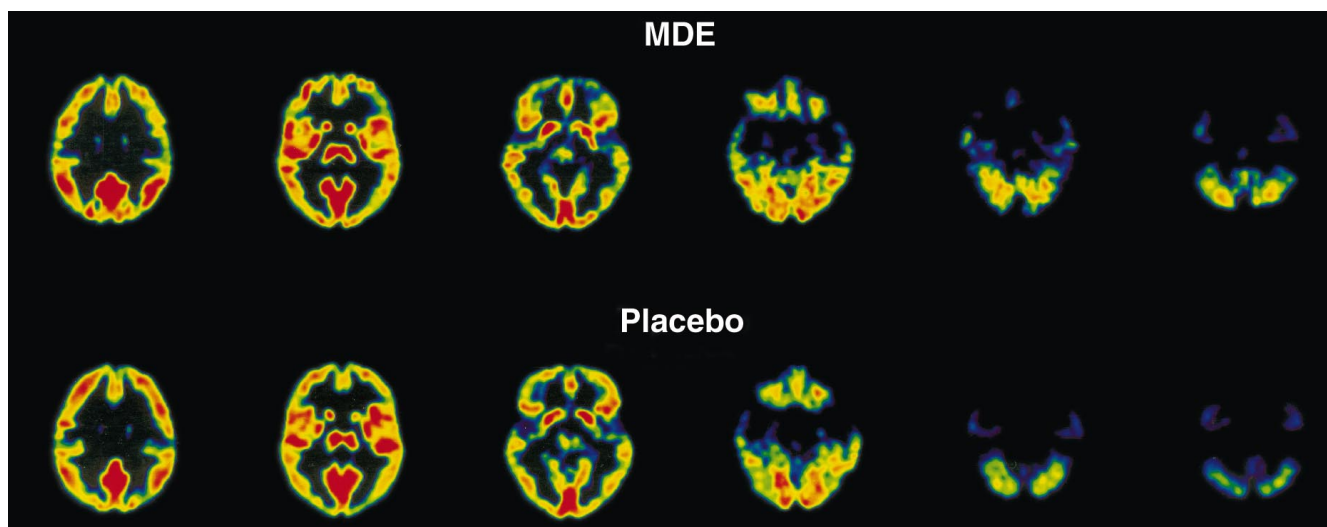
Top row Transaxial ^{18}F FDG PET slices (normalized to global glucose metabolism) under MDE; bottom row corresponding slices under placebo. There is decreased bifrontal and increased cerebellar glucose metabolism under MDE. The (statistically significant) metabolic increase of the right putamen is not clearly visible
